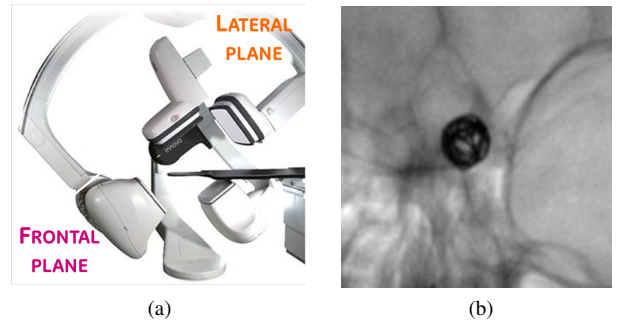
(a) GE Healthcare IGS 630 biplane acquisition system. (b) X-ray projection of a single intra-cranial micro-coil
